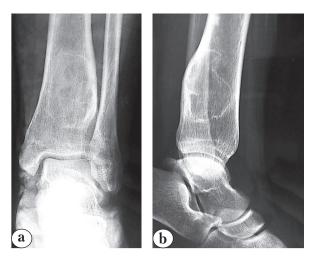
Preoperative plain radiographs, anteroposterior (*a*) and lateral (*b*) views showing the huge intraosseous lesion, encroaching to >50% of the distal tibia, with surrounding sclerosis
